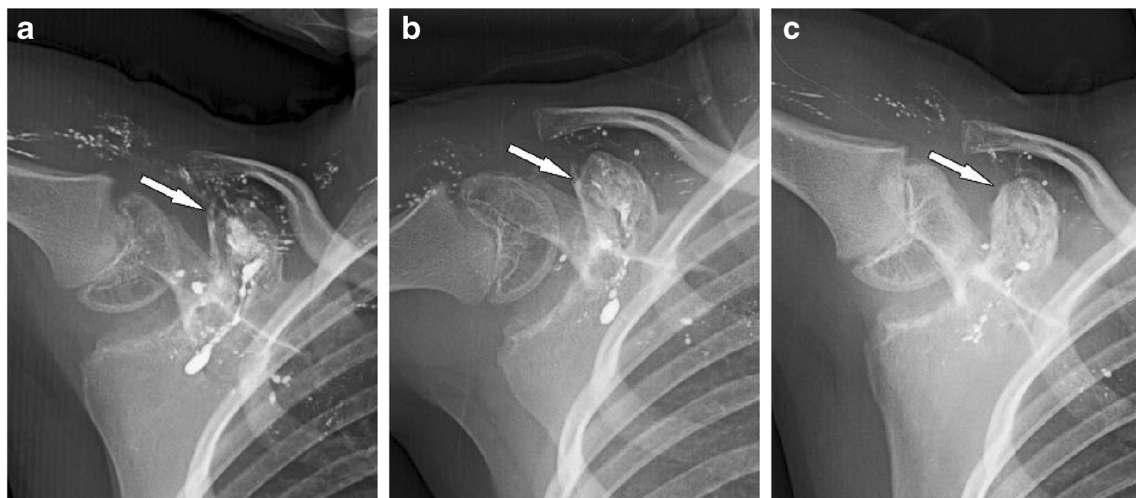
Annual follow-up over 3 years (a 1 year after the procedure; b 2 years after the procedure; c 3 years after the procedure) with anteroposterior radiographs of the right shoulder shows progressive
